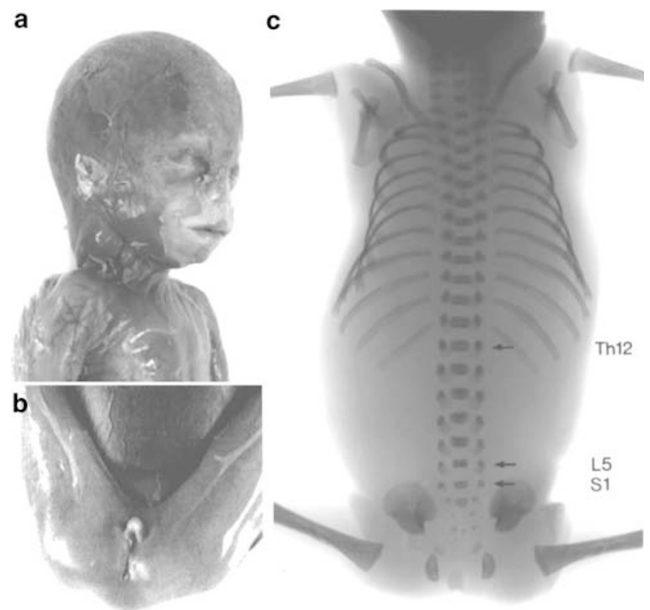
(a–c) Severely macerated female fetus of 18 + 1 gestational weeks showing (a) mildly dysmorphic features with high front, short flat nose, broad nasal root, prominent philtrum, macrostomia, thick lips, microretrognathia, small ears and (b) genital hypoplasia and an ectopic, ventrally placed anus. (c) X-ray revealed 11 ribs and sacral hypoplasia, with only two ossified vertebral bodies.
